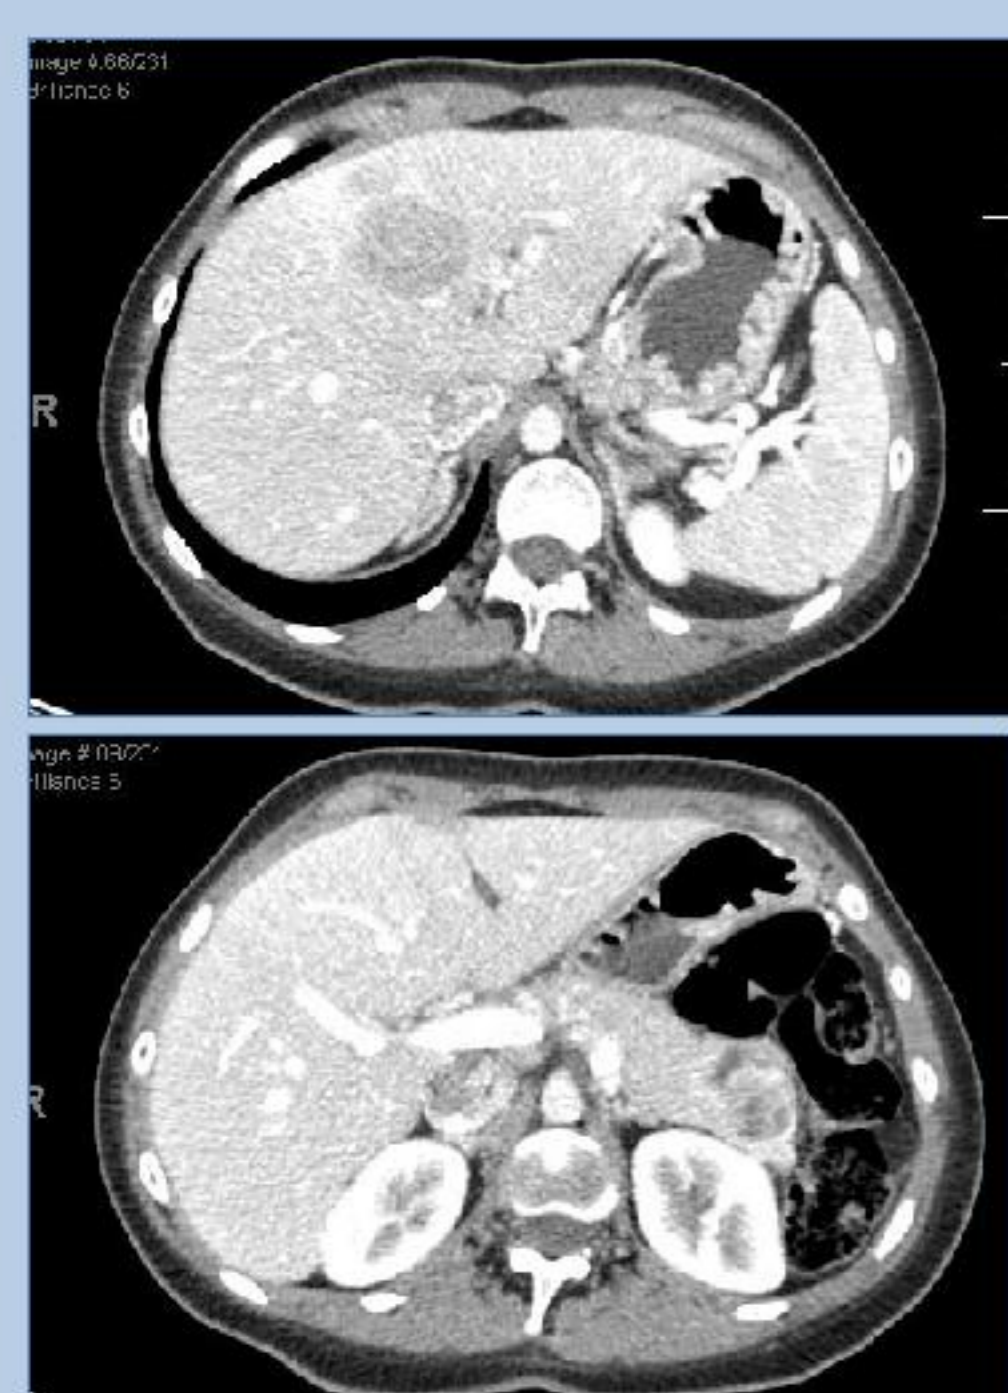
Thoraco-abdominopelvic-CT
